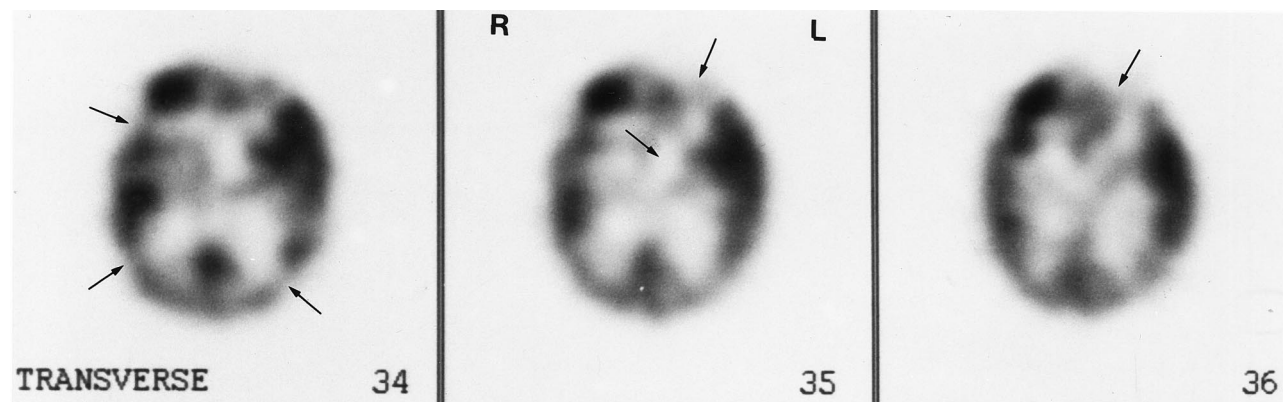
55-year-old woman with rapidly progressive dementia. Axial views from SPECT brain scan after intravenous administration of 25 mCi (925 MBq) ^{99m}Tc -HMPAO show a region of absent perfusion in the anterior left frontal lobe, with diminished perfusion in the posterior right frontal lobe, the left basal ganglia, and the parietal and occipital lobes bilaterally (arrows). Perfusion is relatively normal in most of the right frontal lobe.
